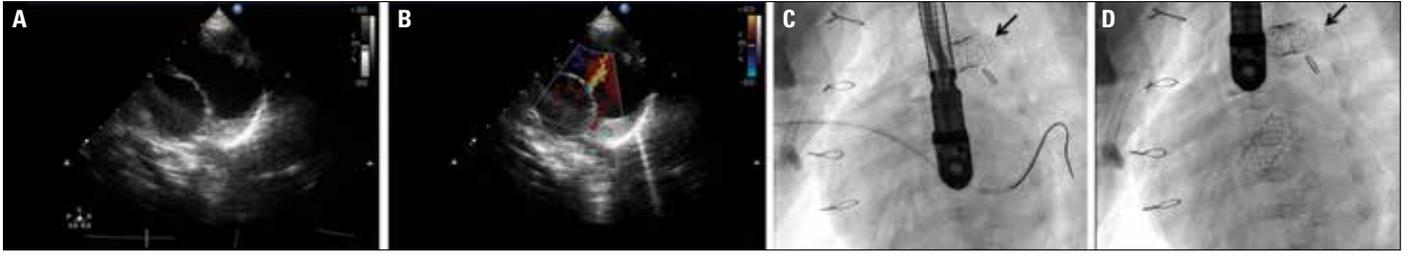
A-D. (A) 2D echocardiographic view of interatrial septum; the bulging to the right side. (B) Color Doppler echocardiographic view of interatrial septum; notice the restrictive color jet. (C) Angiographic view guidewire and sheath passing through the interatrial septum; arrow shows a patent ductus arteriosus stent. (D) Angiographic view after deploying the interatrial stent; arrow shows a patent ductus arteriosus stent
